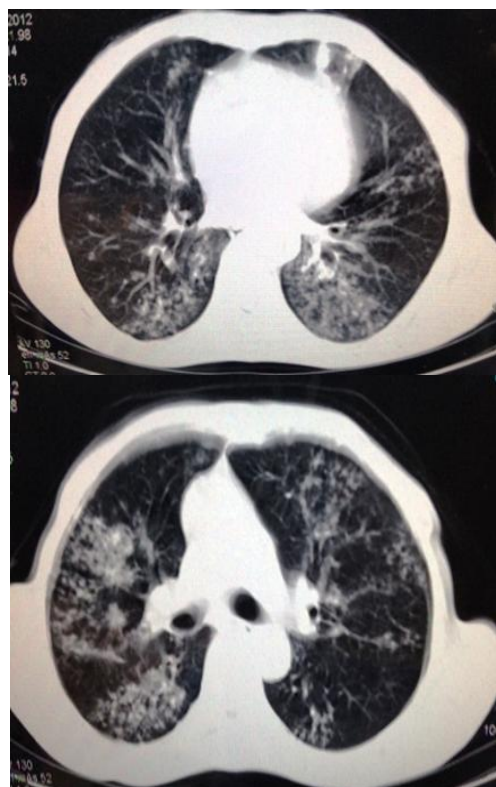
Computed Tomography with showed a bilateral interstitial infiltrate.
